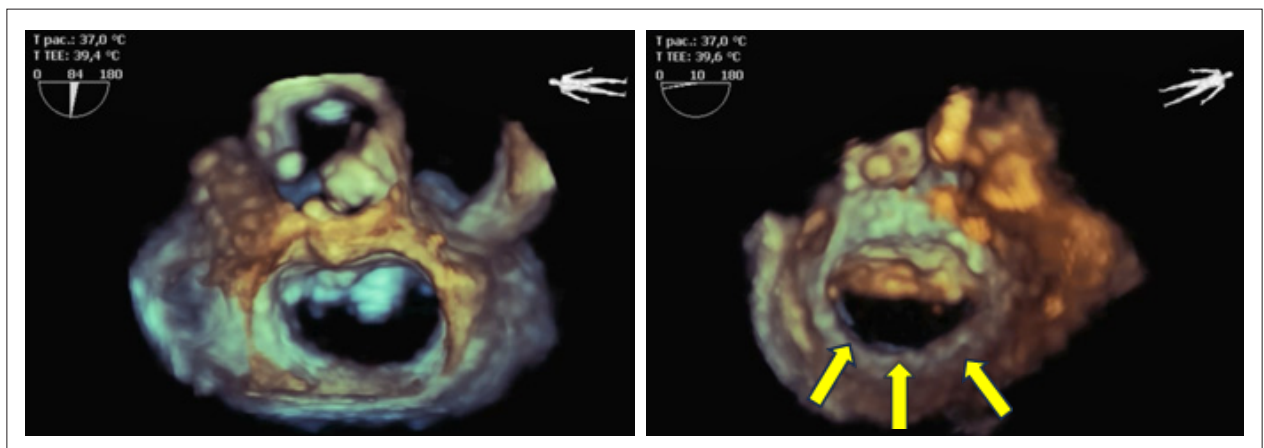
Three-dimensional transesophageal echocardiography with atrial and ventricular views of the mitral valve demonstrating complete posterior leaflet hypoplasia (segments P1, P2, and P3 – yellow arrows).
